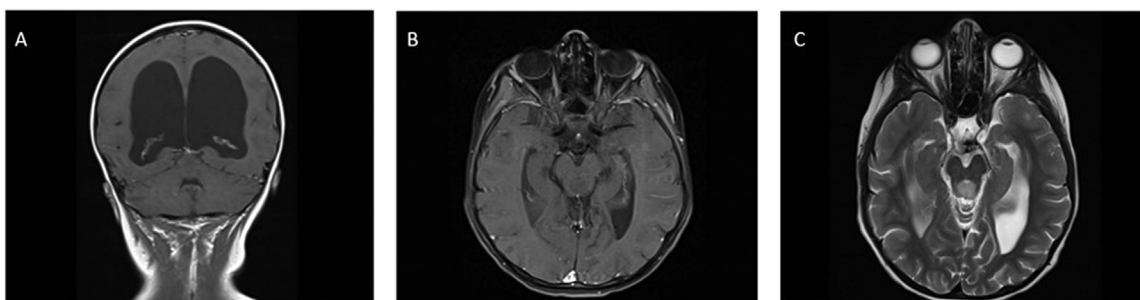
(A) On a coronal T1 sequence magnetic resonance imaging (MRI), an isointense mass can be seen at midline along with resultant hydrocephalus. (B) On an axial T1c sequence MRI, lack of contrast enhancement is noted. (C) On an axial T2 sequence MRI, the mass is clearly visible secondary to its hyperintensity.
